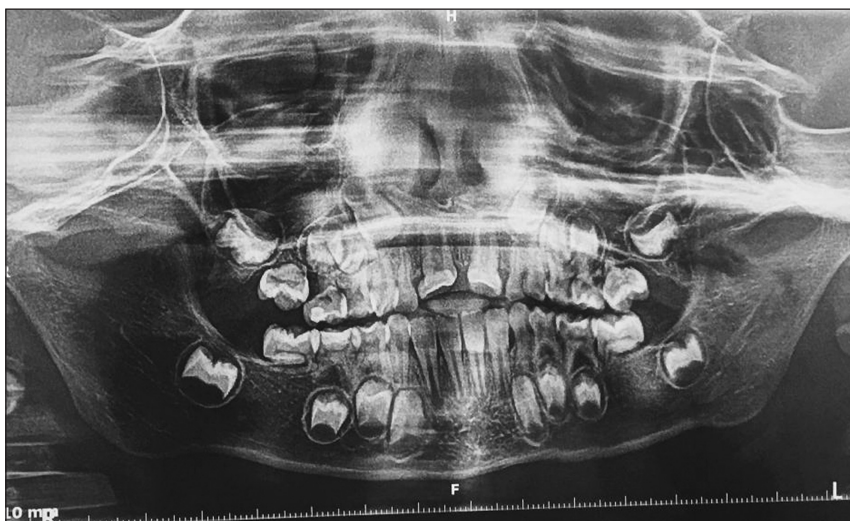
Case two panoramic radiograph. Note the cervical constriction, flattened pulp chambers and absent roots on all permanent first molars. The primary second molars were also affected. Note the congenitally missing maxillary lateral incisors and crown dilaceration of the permanent central incisors.
